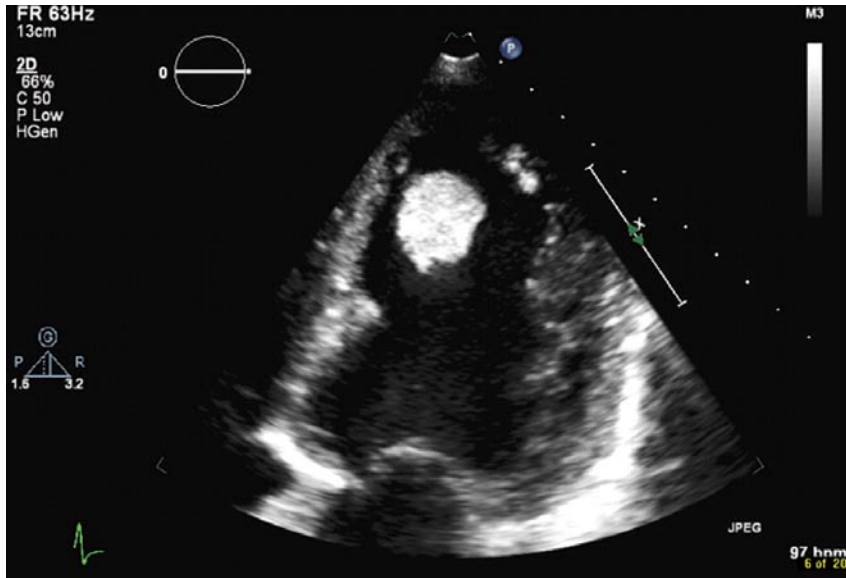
Transthoracic echocardiogram demonstrated a large left ventricular thrombus. It was highly mobile and the risk of embolization was considered to be high.
